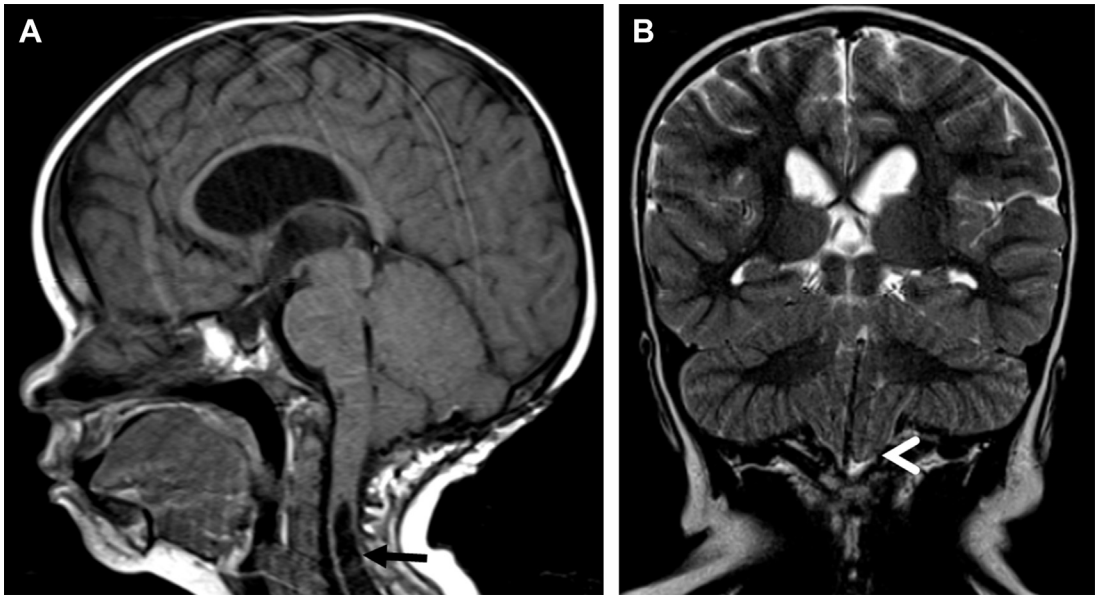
6-year-old boy with CoS status post cervicomedullary decompression. (A) Sagittal T1-weighted image shows inferior descent of the cerebellar tonsils, postsurgical changes associated with decompression, and a cervical region syrigo-hydromyelia (arrow). (B) Coronal T2-weighted image shows inferior descent of the cerebellar tonsils (arrowhead).
